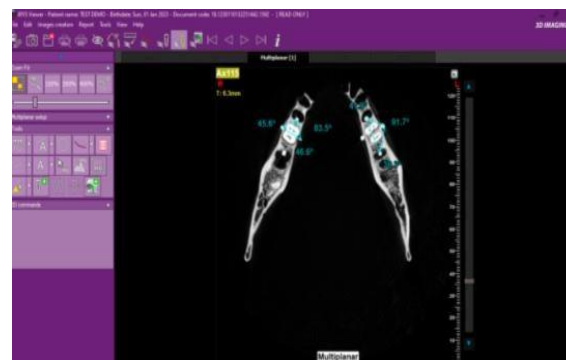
3-D reconstructed image obtained by iRYS software of MYRAY CBCT machine.
